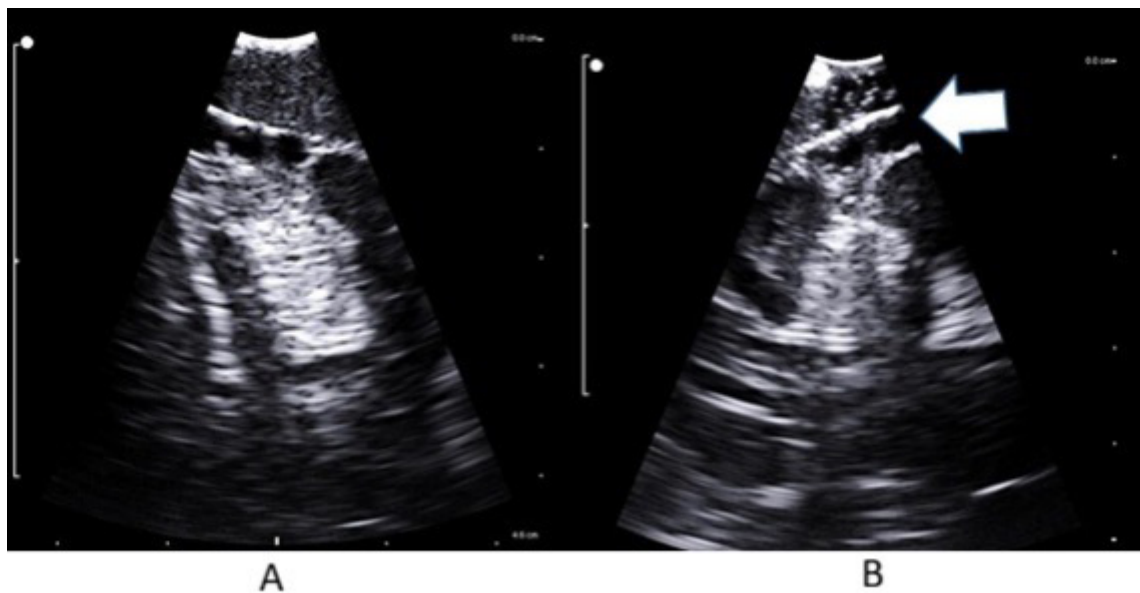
An example of residual following irrigation: A) Pre-drainage ultrasound demonstrating double layer of hematoma of differing densities – the deep hematoma showed trabeculations not seen on CT scan; B) Residual layer overlying cerebral cortex despite repeat irrigation; White arrow: No membrane manipulation was attempted here; Arrows are pointing at the hematoma layer.
